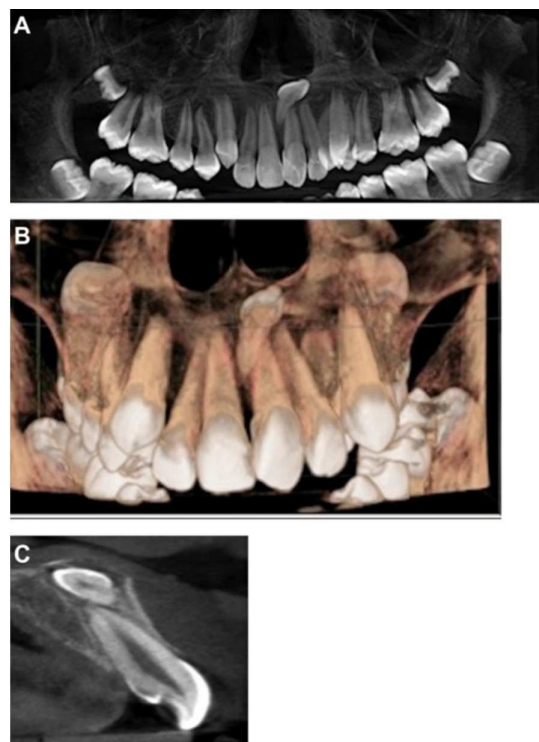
CBCT images (panoramic/3D reconstruction/cross-sectional) eases treatment planning for impacted mesiodens. (A) Panoramic radiograph showing mesiodens. (B) 3D reconstruction showing impacted mesiodens. (C) Cross sectional view showing relation of impacted mesiodens with central incisor.
